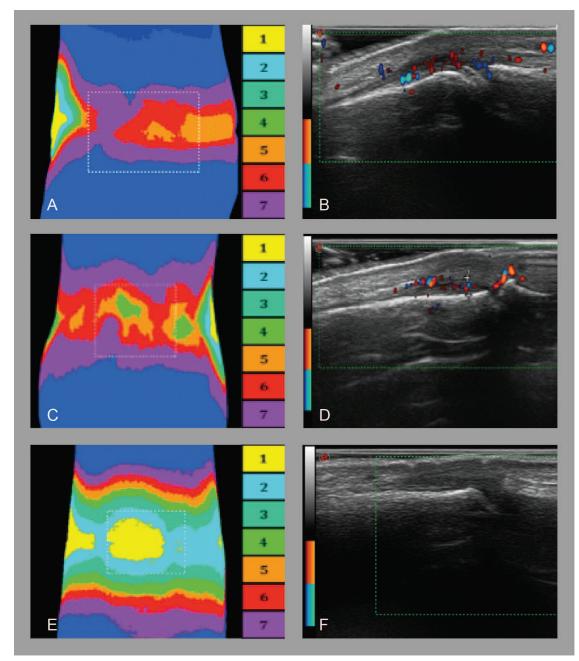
POI and PDUS findings in OA (A + B), active RA (C + D), and a healthy subject (E + F). A. An increased POI score of 5 in the PIP joint 2 of the left hand in a patient with OA. B. PDUS of the PIP joint 2 of the left hand in the same patient with OA, dorsal view with synovitis PDUS Grade 2. C. An increased POI score of 4 in the PIP joint 2 of the right hand in a patient with RA. D. PDUS of the PIP joint 3 of the left hand in a healthy subject. F. PDUS of PIP 2 of the right hand in the same healthy subjects without any inflammatory sign in US, PDUS Grade 0. POI: photo optical imaging; PDUS: power Doppler ultrasonography; OA: osteoarthritis; RA: rheumatoid arthritis; PIP: proximal interphalangeal.
